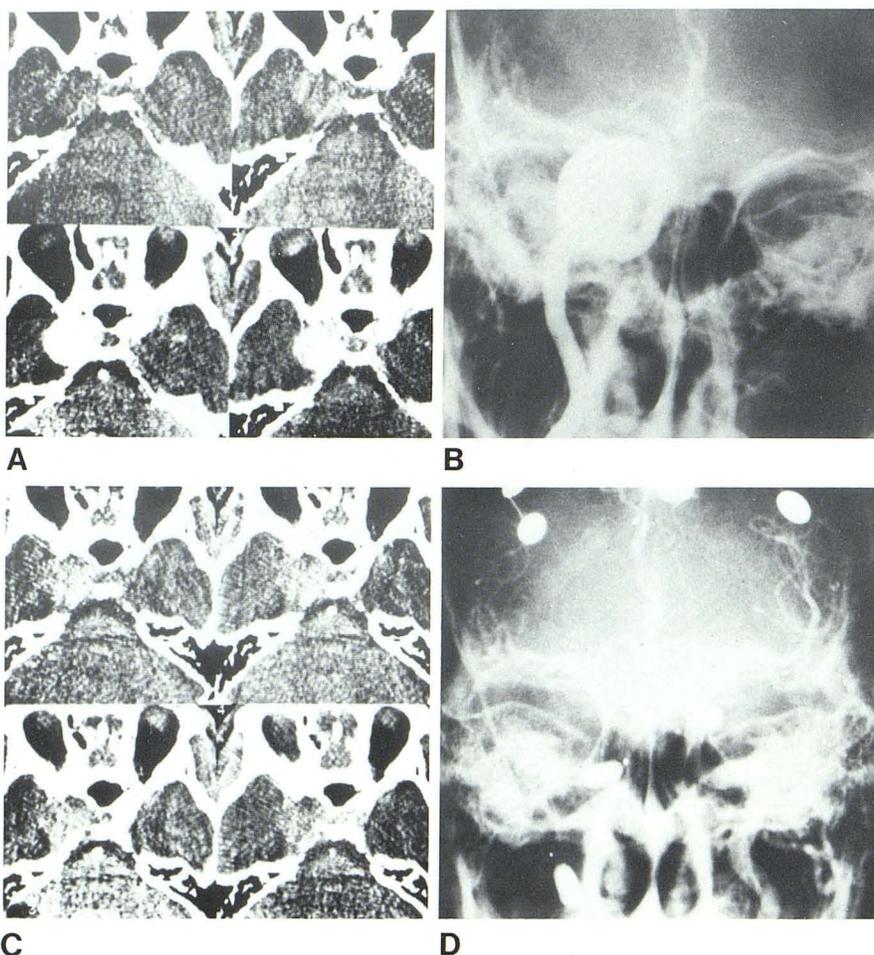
Giant intracavernous aneurysm. A, Dynamic CT scan before treatment. High-density enhancing mass in right parasellar region. B, Right internal carotid angiogram. Huge aneurysm in cavernous part of artery. C, CT after transcatheter balloon catheterization and occlusion of right internal carotid artery. Only faint rim around mass. D, Left internal carotid angiogram. Good left-right cross-flow. (Disks are EEG electrodes for intravascular occlusion test.)
